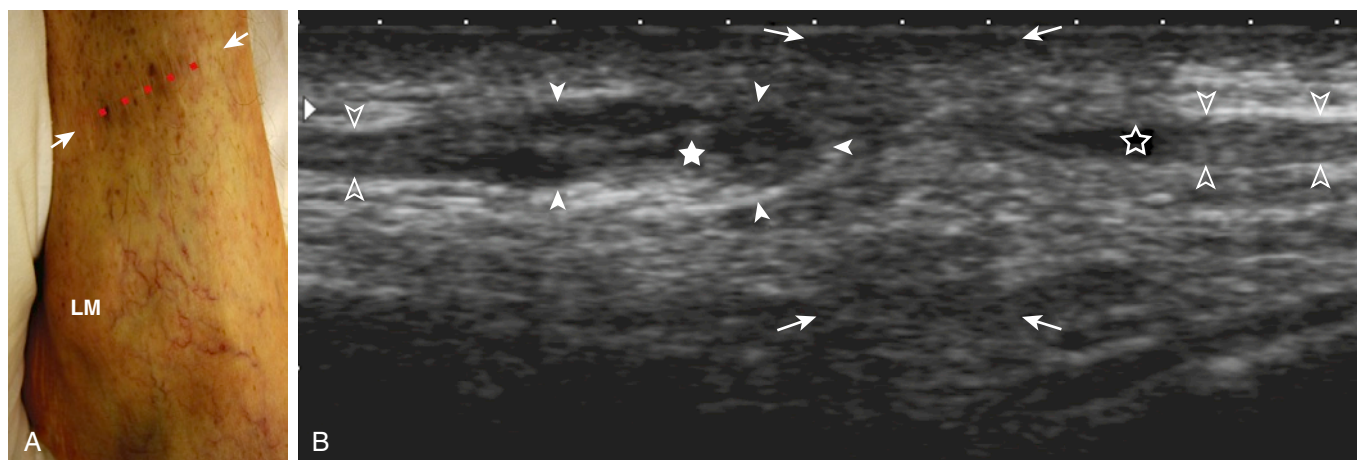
SUPERFICIAL PERONEAL NERVE COMPLETE SECTION. A, Clinical picture shows a scar (dotted line) that formed after trauma to the lateral aspect of the distal leg. B, Long-axis, 5- to 14-MHz ultrasound image shows complete interruption of the superficial peroneal nerve (open arrowheads) with a larger (closed arrowheads) proximal neuroma (closed star) and a smaller distal neuroma (open star). Notice the scar tissue (arrows) between the two neuromas. LM, lateral malleolus.
